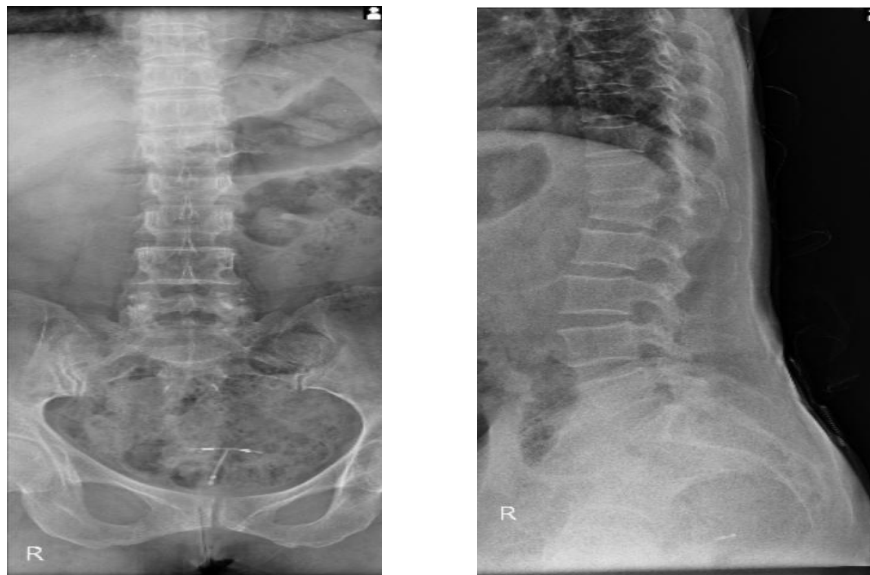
Lumbosacral X-ray (AP/Lateral views) shows a compression fracture of L1.
